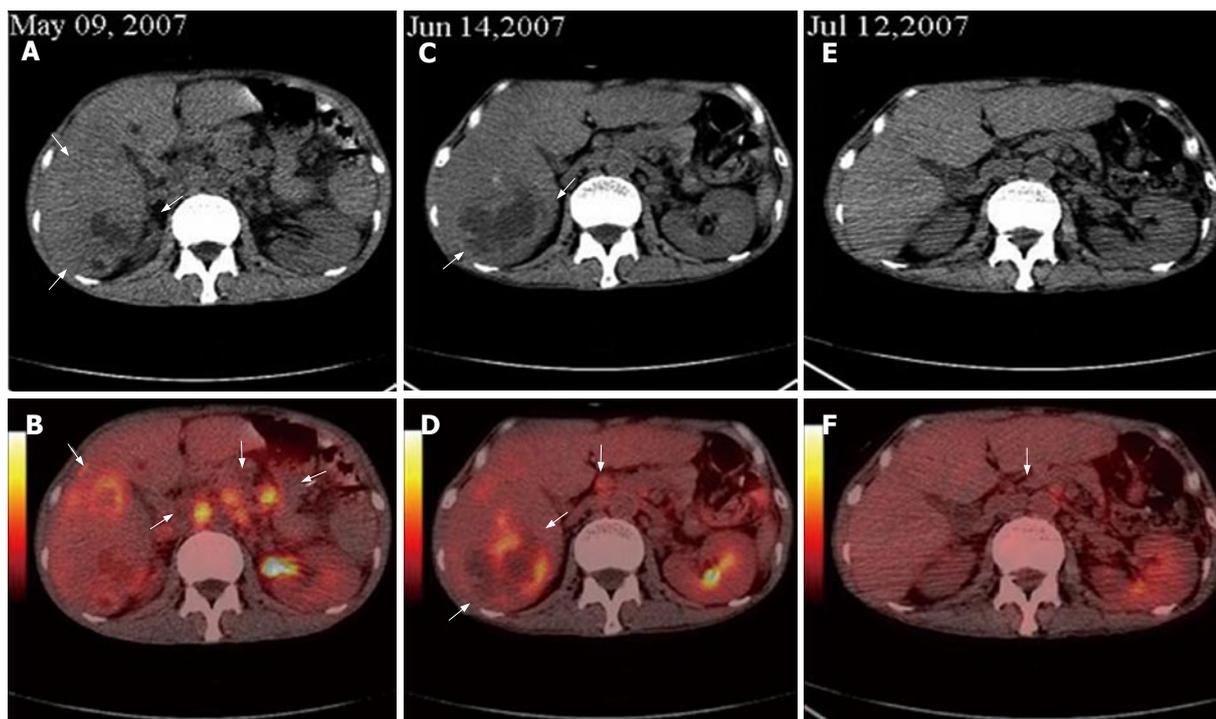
Base line FDG PET/CT detecting huge metastases in the right lobe of liver and highly metastatic lymphoid nodes in abdomen (white arrows, A and B), second FDG PET/CT demonstrating huge metastases in the right lobe of liver and the decreased number, size and metabolism level of metastatic lymphoid nodes (white arrows, C and D), third FDG PET/CT displaying the disappeared huge metastases in the right lobe of liver and the normal size of metastatic lymphoid nodes (E and F).
